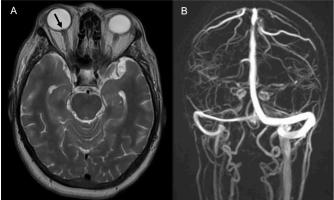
(A) T2-weighted axial brain MRI shows protrusion of the optic nerve-head towards the globe on the right, consistent with intracranial hypertension. (B) Normal MR venography; no evidence of venous thrombosis was observed.
